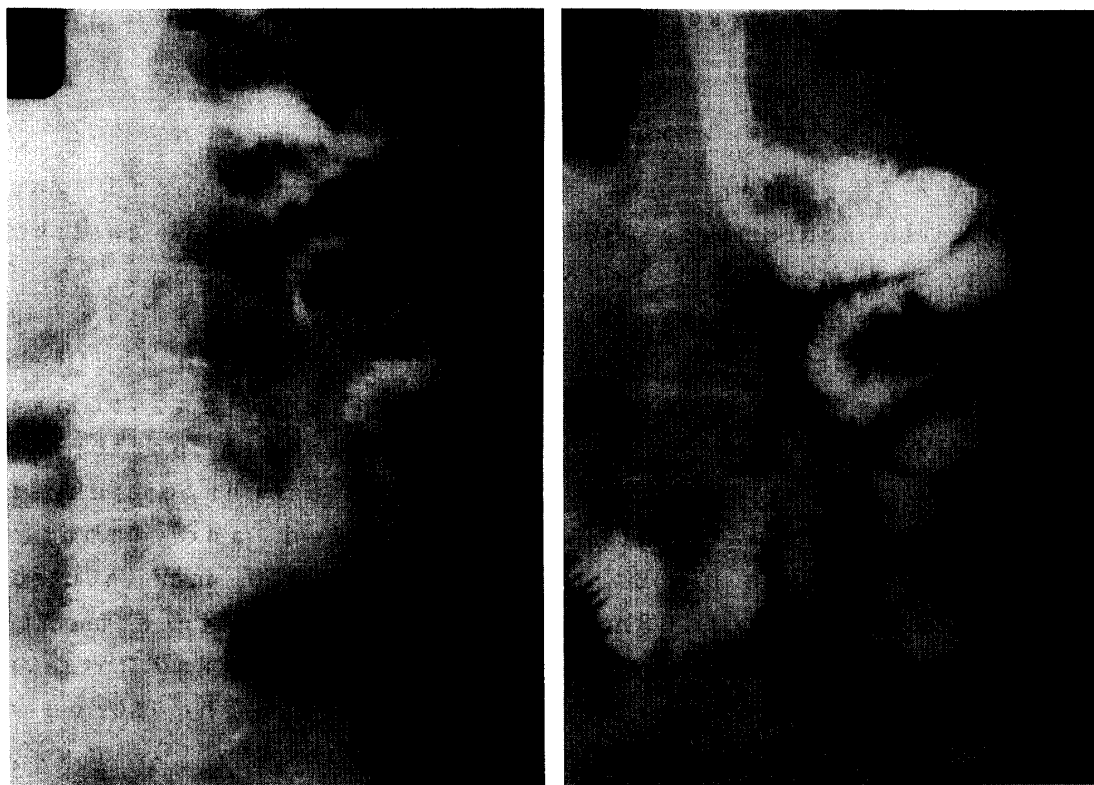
Postoperative barium X-ray study of gastrointestinal series (GIS) before and after administration of terbutaline in case 1. GIS on the 11th postoperative day revealed a major leakage (↑) from the jejunojejunostomy (left panel). After treatment, GIS on the 34th day showed complete healing of anastomotic leakage (right panel).
